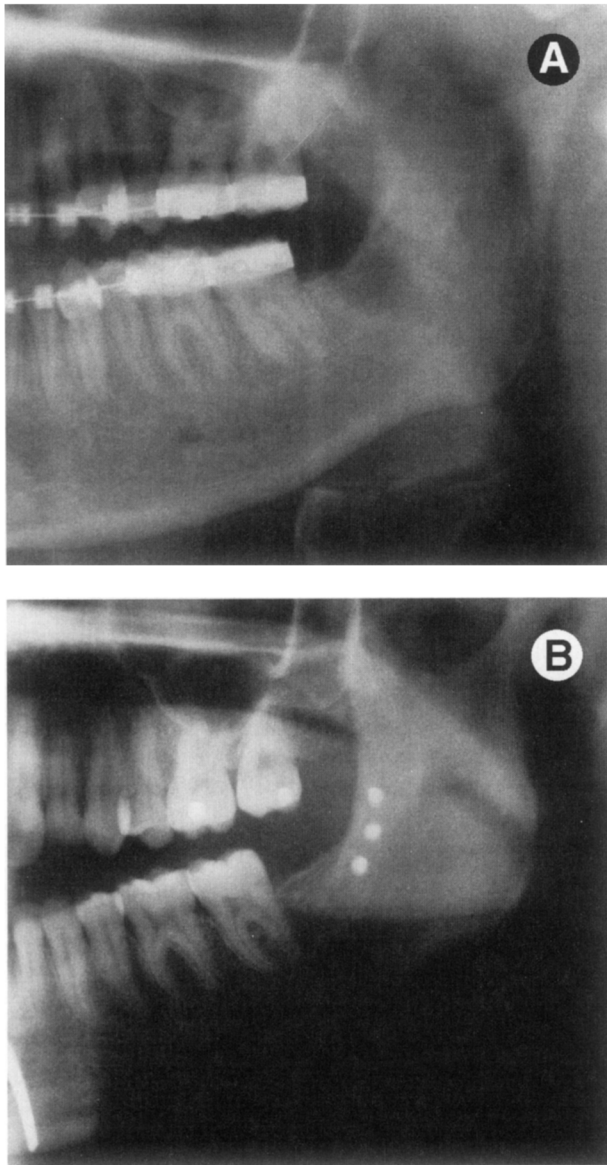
A, Preoperative and B, 5-year postoperative panoramic radiographs of a patient with greater than 30% of original condylar height.
